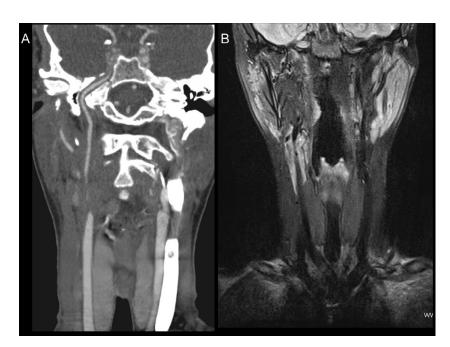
(A) Coronal reconstructed computed tomography angiography and (B) coronal T2-weighted image with fat saturation magnetic resonance images demonstrated nearly complete occlusion in the bulbar segment of the right common carotid artery and right internal carotid artery thickening, respectively.
